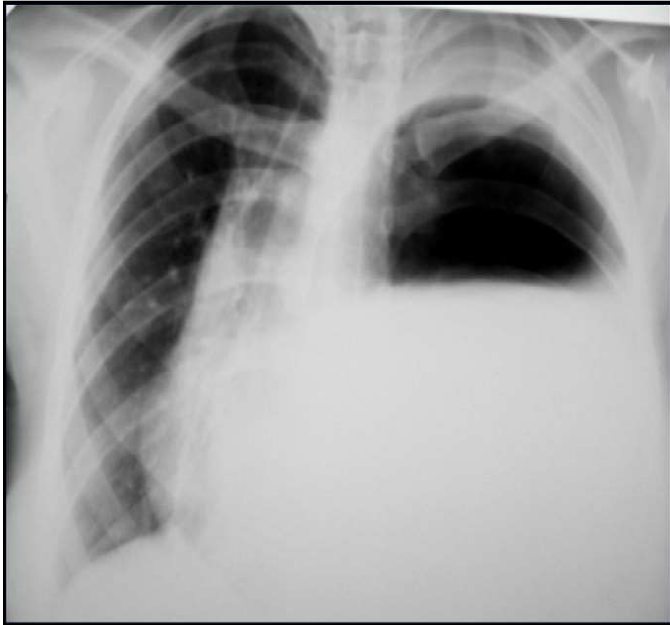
X-ray of the patient's chest.
